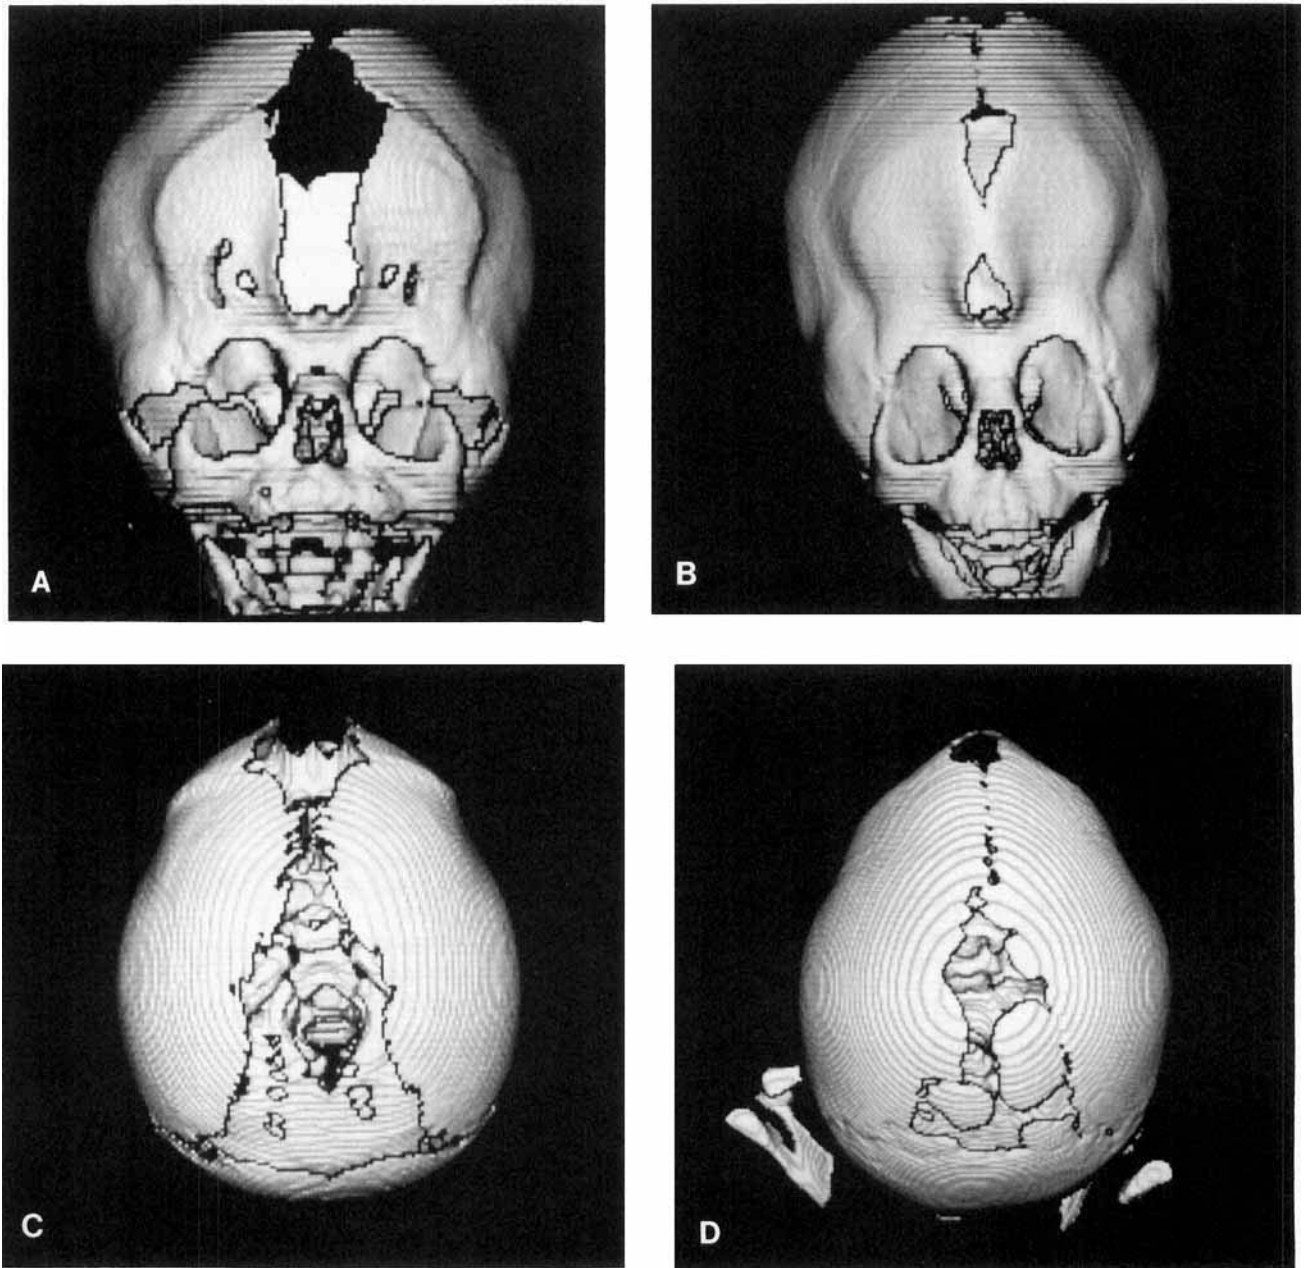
Three-dimensional reconstruction of CT scans in an Apert infant. A: Extensive midline calvarial defect and unusually large anterolateral fontanelles extending into orbits at age 1 month. B: Note ongoing closure of midline calvarial defect and closure of anterolateral fontanelles in same patient at age 8 months. C: Calvarial view showing widely patent midline defect at age 1 month. D: Calvarial view of same patient at age 8 months, showing ongoing closure of midline defect with coalescence of bony islands; no proper suture formation.
